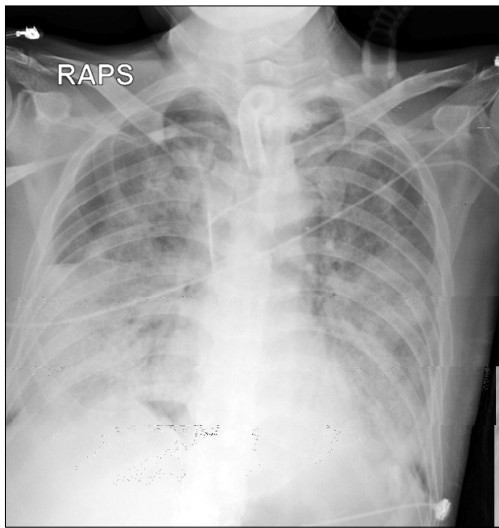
Chest X-ray showed extensive diffuse multifocal infiltration in both lung fields.
